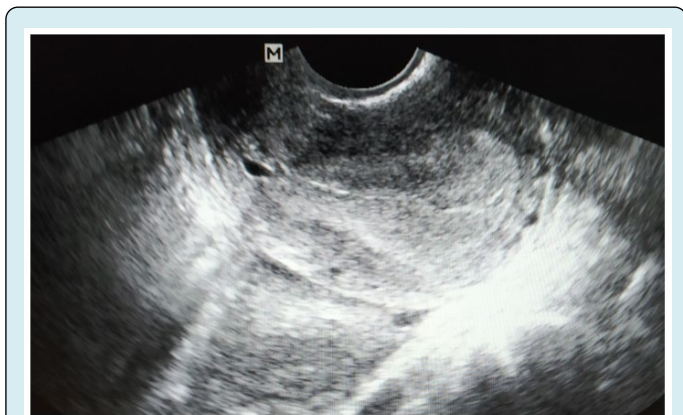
Transvaginal ultrasonographic image showing thick endometrium with gestational sac (corresponding to 4 weeks 6 days) in cervical canal.
